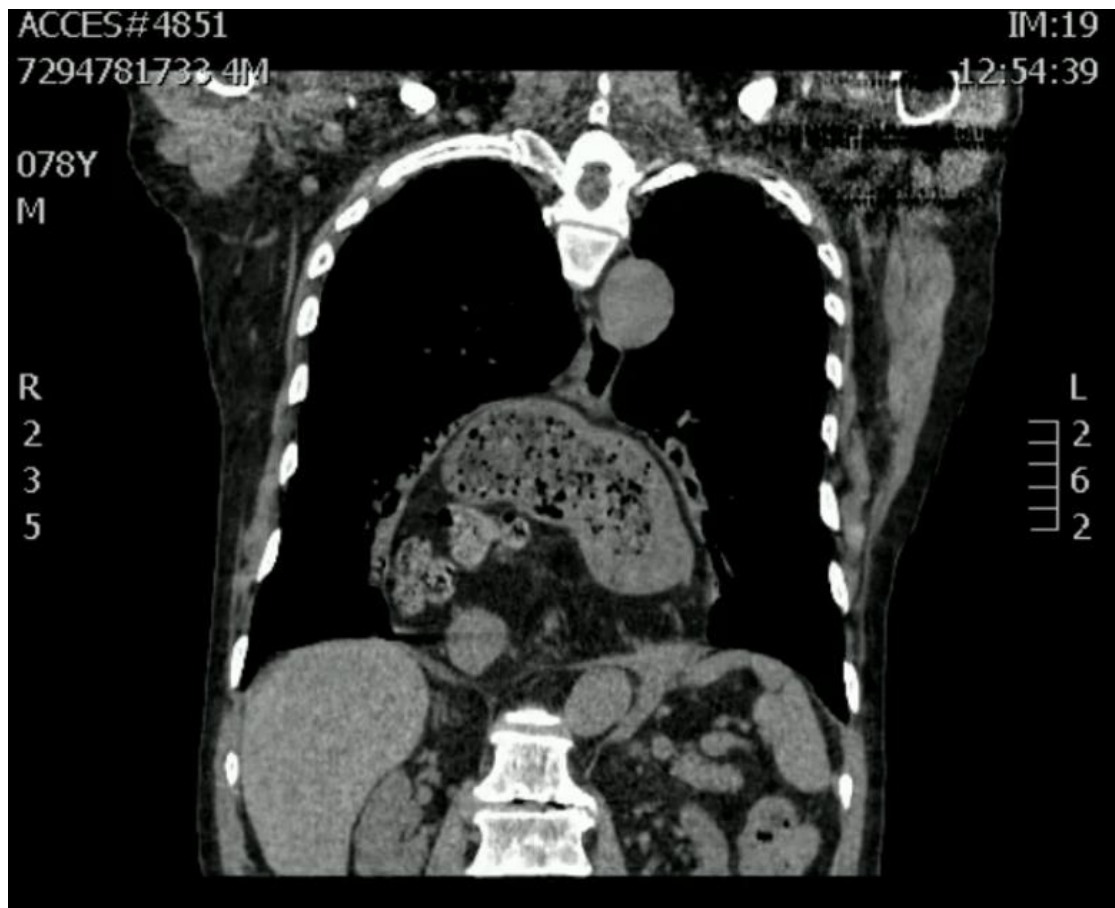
Thoracoabdominal CT scan showing stomach and colon in mediastinum coronal view
